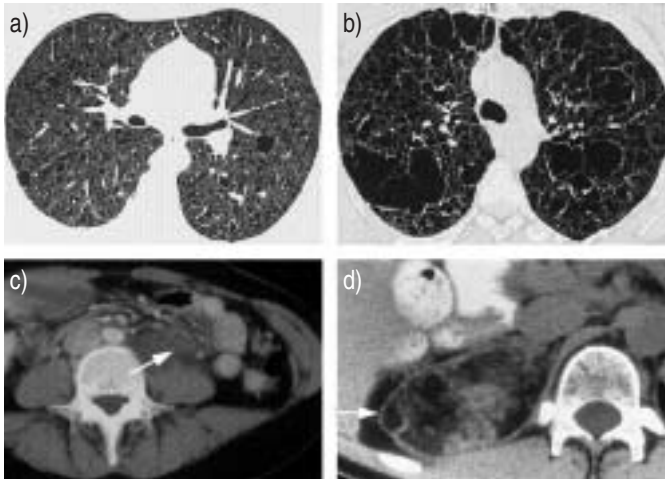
Computed tomography (CT) appearances in lymphangioleiomyomatosis (LAM). a) High-resolution CT showing a moderate degree of pulmonary cysts. The cysts have thin walls and the intervening lung parenchyma is normal. b) Advanced LAM where cysts have coalesced, there is minimal normal lung and the appearance is less characteristic. c) Abdominal CT showing a retroperitoneal lymphangioleiomyoma. The low-density centre of the lesion (arrow) representing fluid appeared cystic using ultrasound scanning (not shown). d) CT appearance of a renal angiomyolipoma (arrow) showing mixed CT density, with the characteristic low attenuation areas representing fat.
